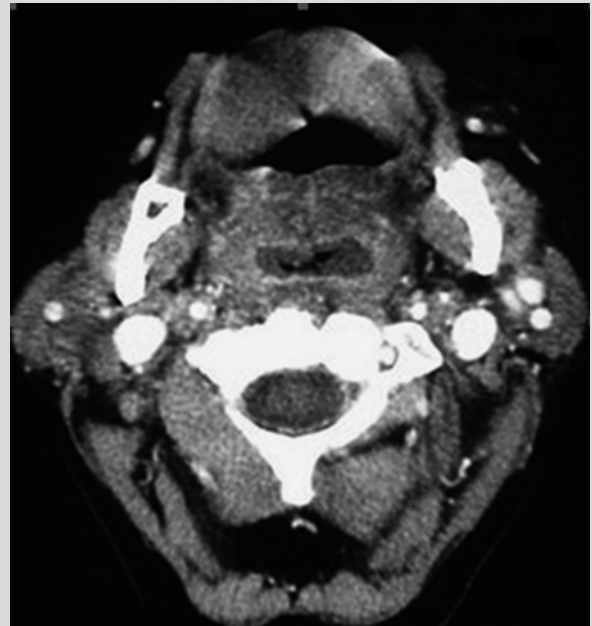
Pharyngeal diphtheria. Enhanced CT scanning of the nasal sinus demonstrated soft tissue swelling of the uvula, the soft palate, the oropharynx, and nasopharynx (Reprint with permission from Khodaei I, et al. *J Laryngol Otol* 2008, 122(12): 1397)
